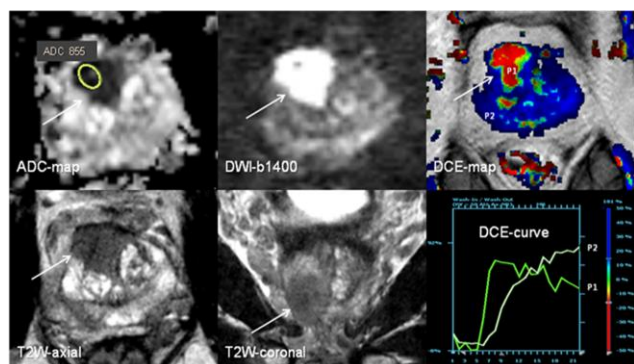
Mp-MRI (T2W, DWI and DCE imaging) shows a tumour suspicious region in the anterior part of the prostate (white arrows) that is considered not to be hit by the systematic TRUS-bx. The region is hypo-intense on T2W imaging, dark on the ADCmap (ADCtumour value 855 ($\times 10^{-6} \text{mm}^2/\text{sec}$)) and bright on the DWI-b1400 indicating a solid tumour mass. The corresponding DCE colour map shows focal enhancement in the region (red area) and the dynamic DCE-curve (P1) is a typical malignant (type 3) curve with rapid early enhancement and early wash-out. The DCE-curve (P2) is from a non-malignant region. The region was classified as high suspicion of prostate cancer (PIRADS summation score 5-5-5, overall Likert score 5).
